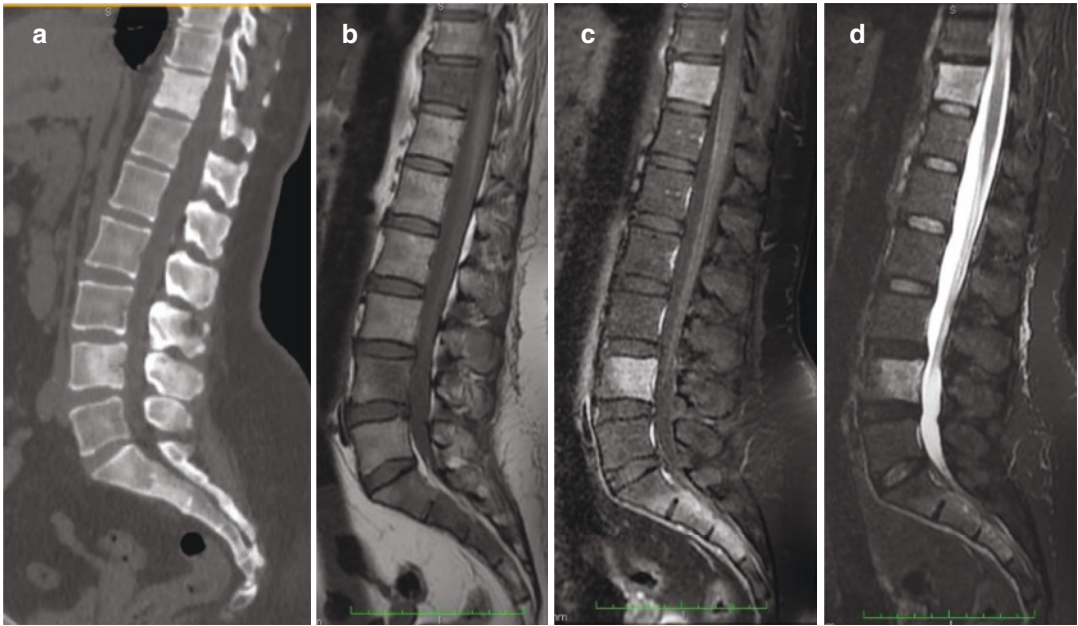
Multifocal tuberculous spondylitis (vertebral osteomyelitis). Sagittal (a) CT and (b) T1-W, (c) contrast-enhanced fat-suppressed T1-W, and (d) STIR MR images
